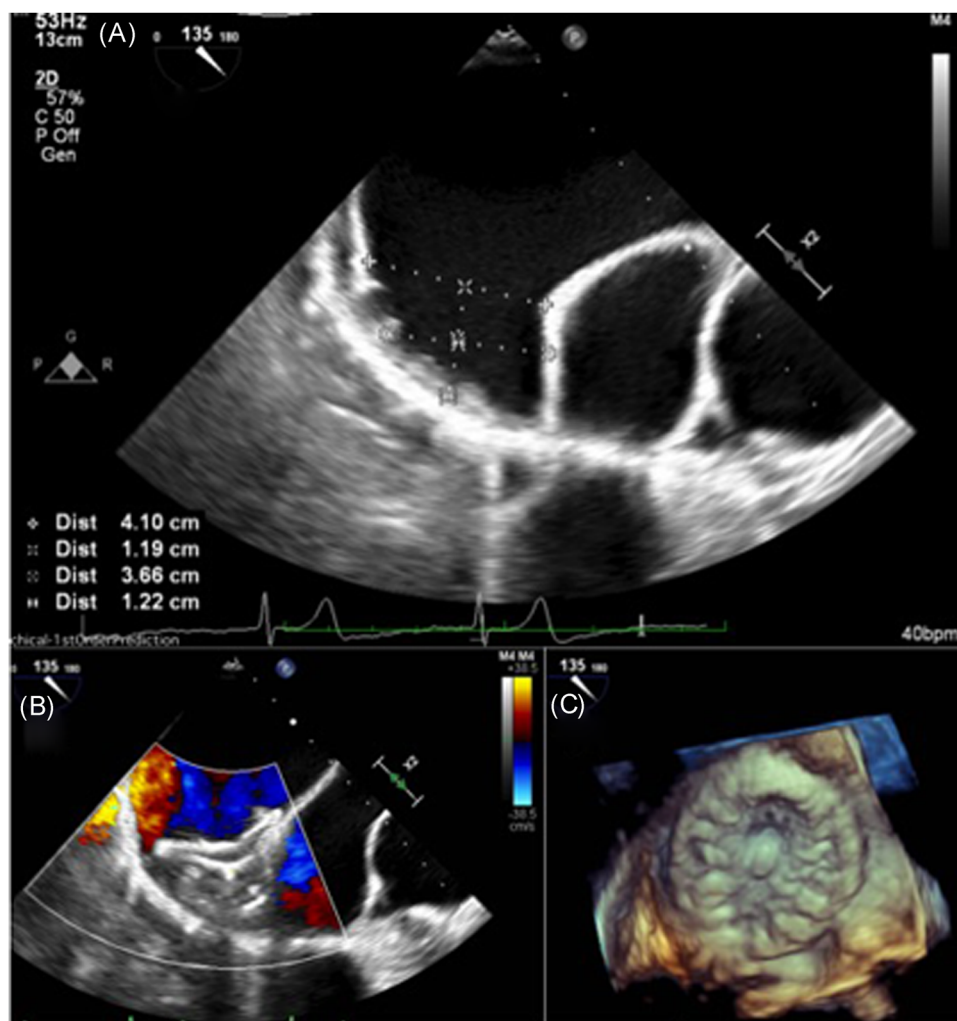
Pre- and post-TEE images: (A) Preprocedural TEE at 135° showed measurements of 41 mm in width and 24.1 mm in depth. (B) Postprocedural TEE showed the proper placement of LAMBRE 30/50 mm with its disk covering the LAA entrance and no significant peri-device leak. (C) Three-dimensional TEE showing the LAMBRE covering the entrance of LAA. LAA, left atrial appendage; TEE, transesophageal echocardiogram
